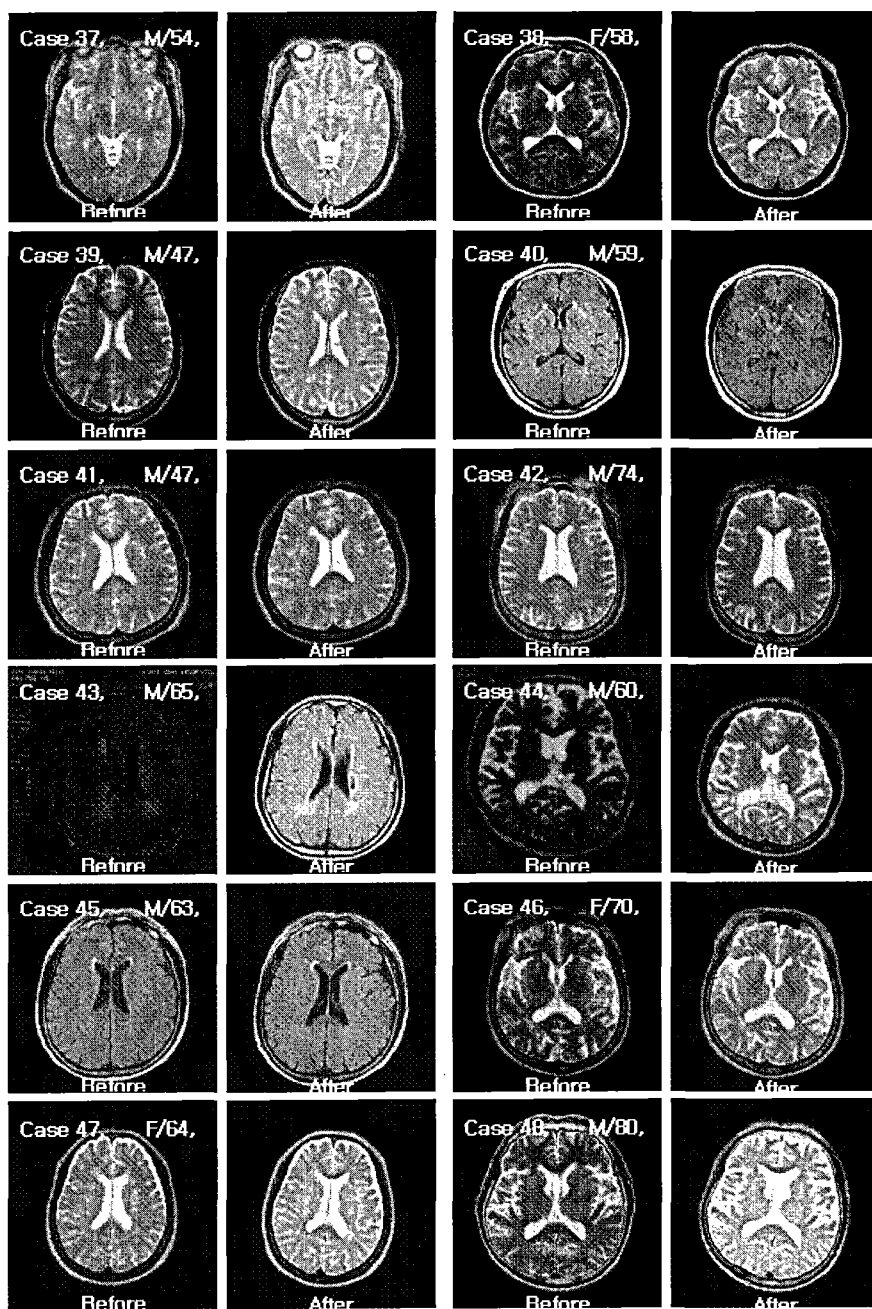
Brain MRI before and after 1 year of *Chunghyul-dan* medication in Cases 37 to 48
